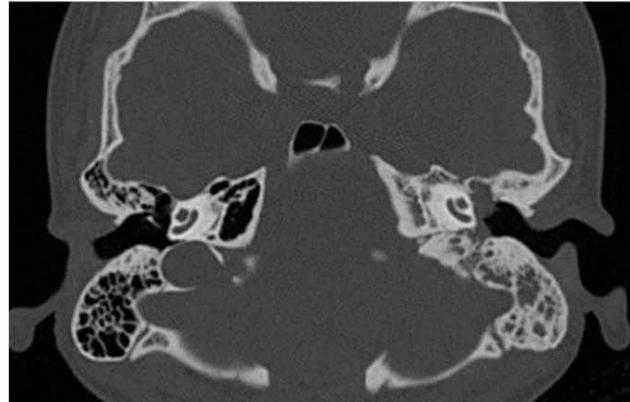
Axial high-resolution temporal bone computed tomography reveals right-sided petrous apex pneumatization and high jugular bulb
